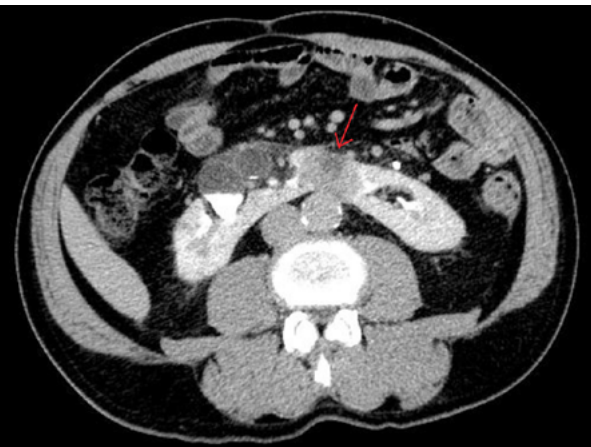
CT scans of the horseshoe kidney
